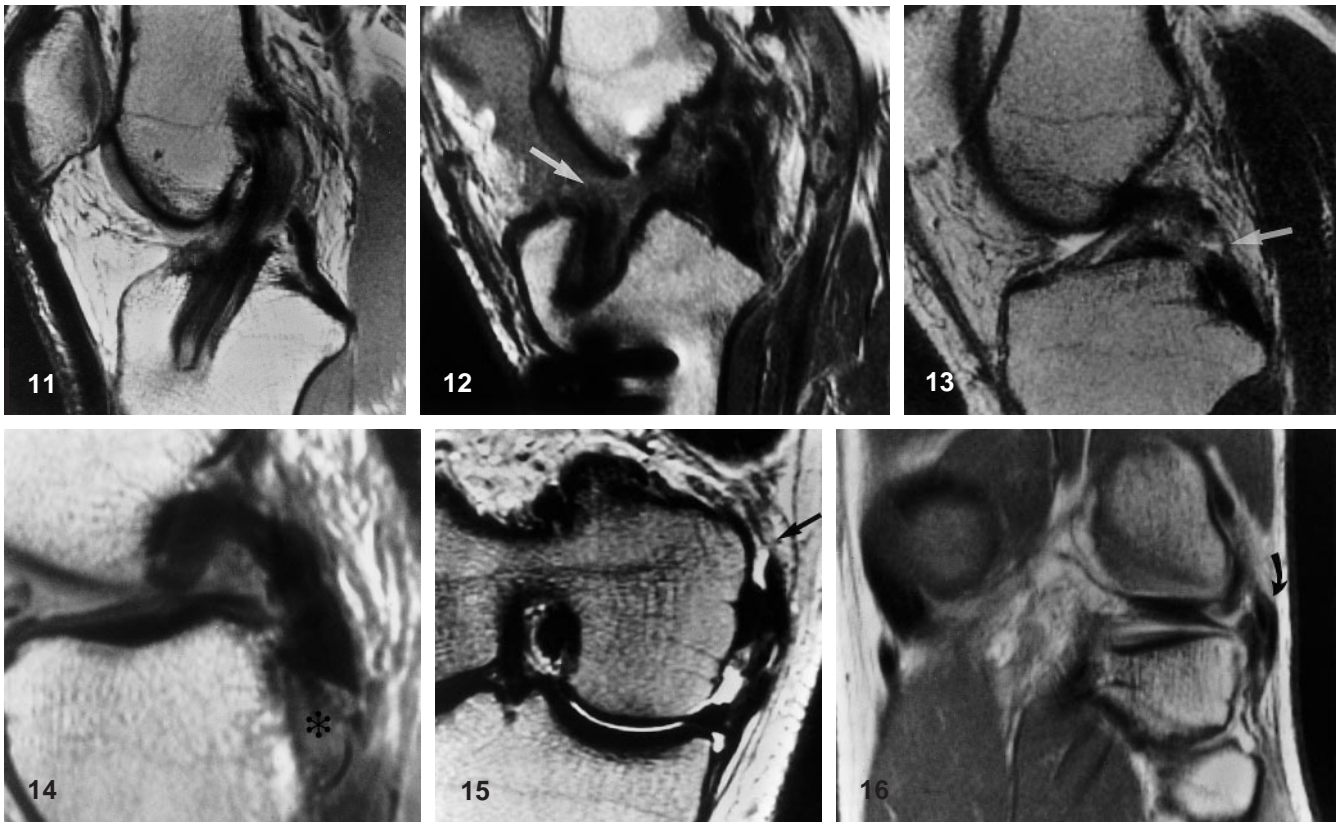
Intact ACL graft. Sagittal proton density MR image (SE 1900/20) showing homogeneous signal throughout the ligament, a straight course into the tibial tunnel, and a smooth transition into the femoral tunnel
